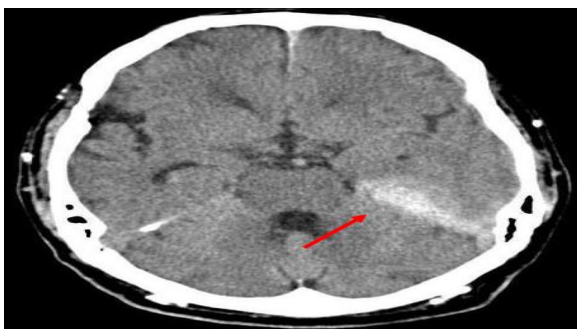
An axial brain CT shows dural thickening adjacent to the petrous part of the temporal bone on the left side (red arrow).
